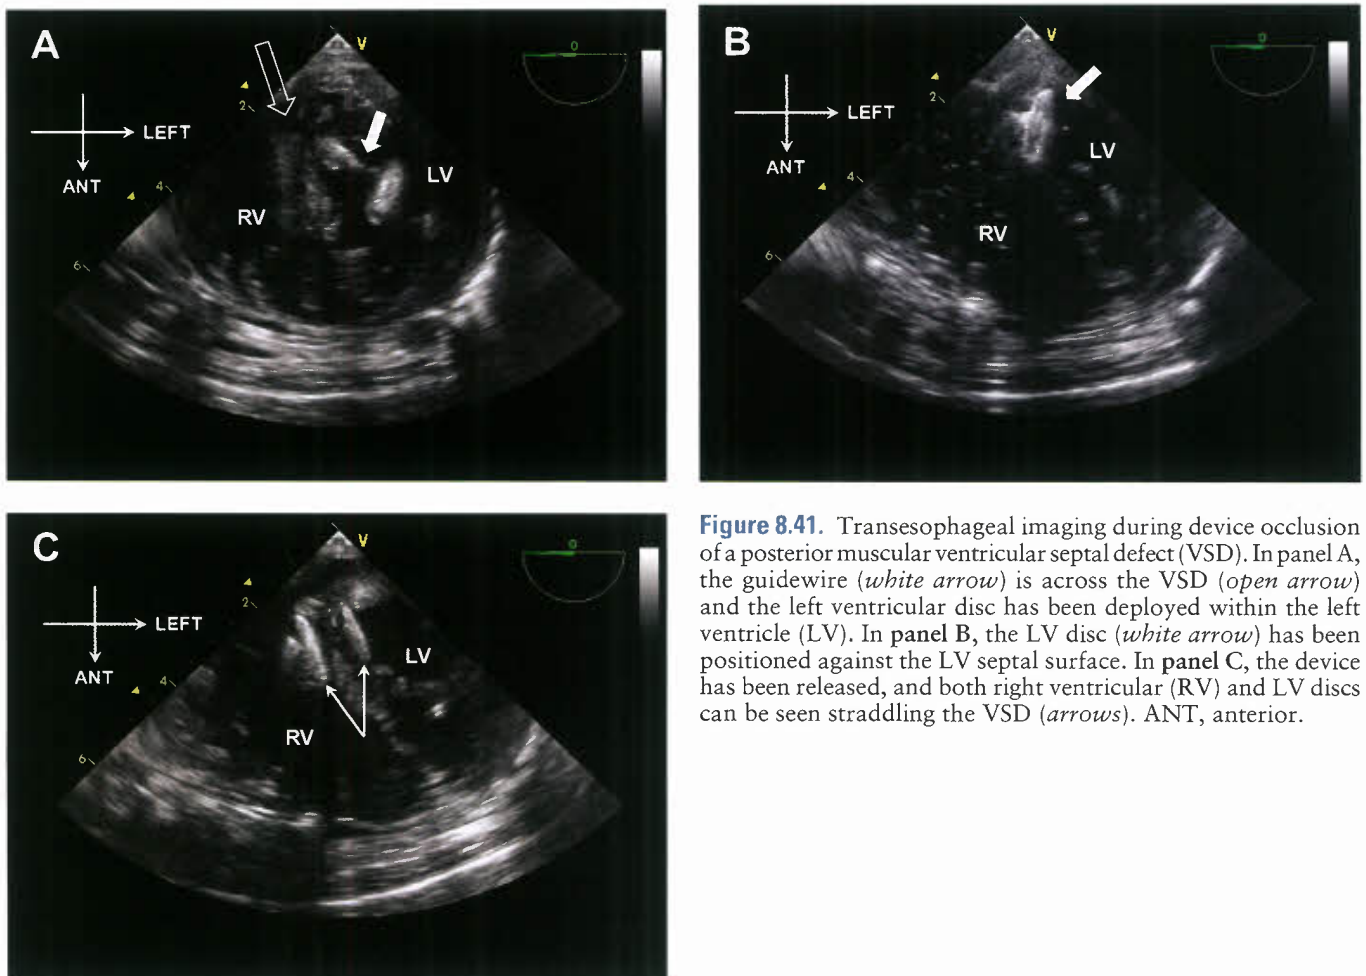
Transesophageal imaging during device occlusion of a posterior muscular ventricular septal defect (VSD). In panel A, the guidewire (*white arrow*) is across the VSD (*open arrow*) and the left ventricular disc has been deployed within the left ventricle (LV). In panel B, the LV disc (*white arrow*) has been positioned against the LV septal surface. In panel C, the device has been released, and both right ventricular (RV) and LV discs can be seen straddling the VSD (*arrows*). ANT, anterior.
